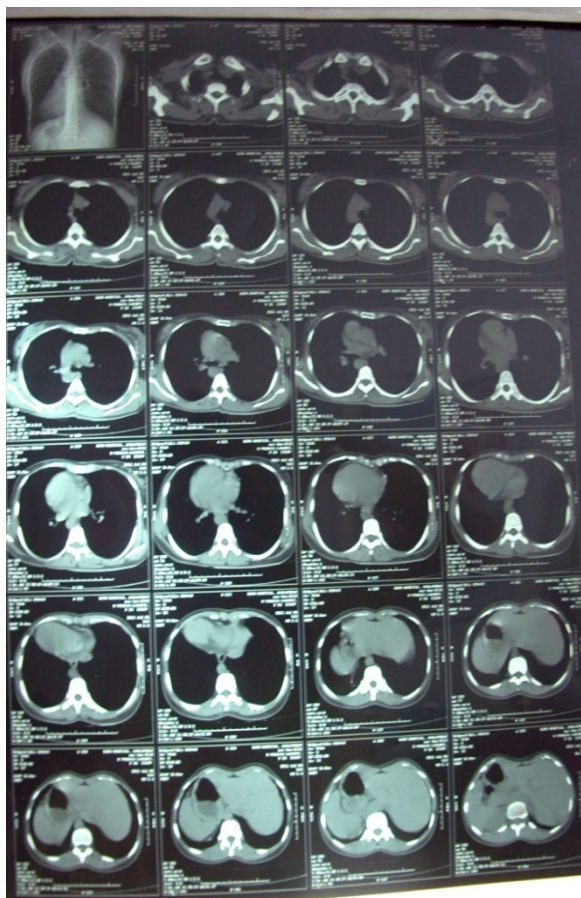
HRCT Thorax-Showing Dextro Cardia and Bronchiectatic changes in lungs
